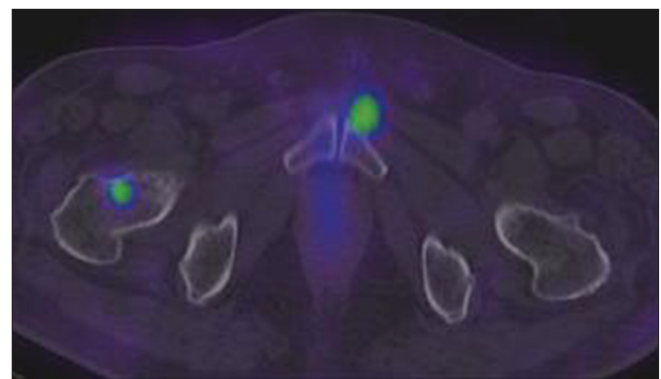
Axial fused single-photon emission computed tomography/computed tomography showing uptake in the neck of right femur and left pubis
